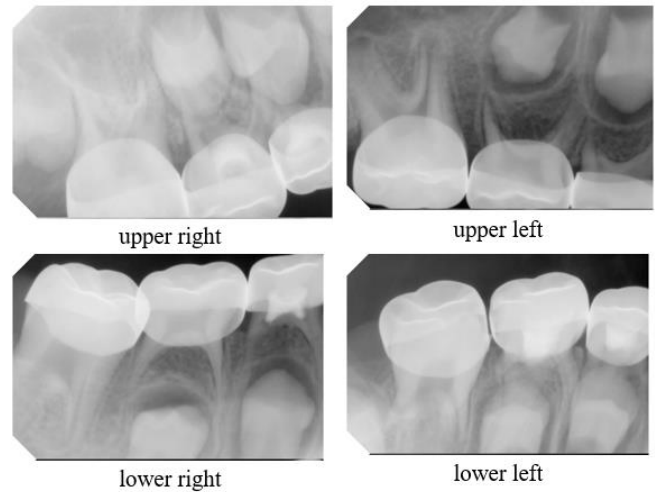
Apical radiography after one year follow-up.
